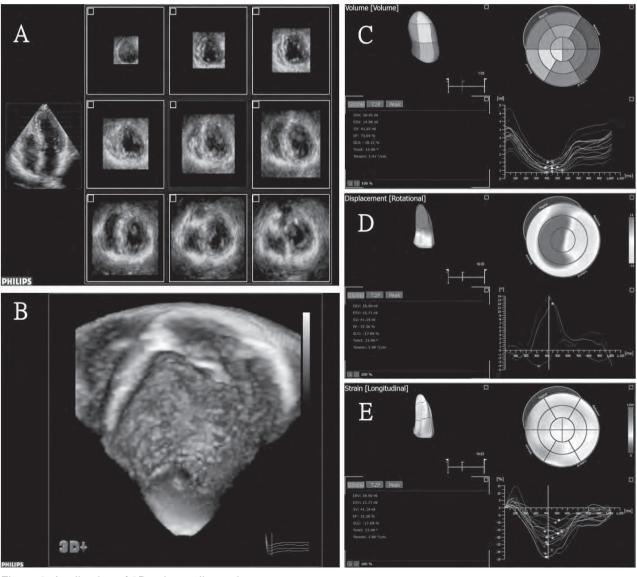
Application of 3D echocardiography.
